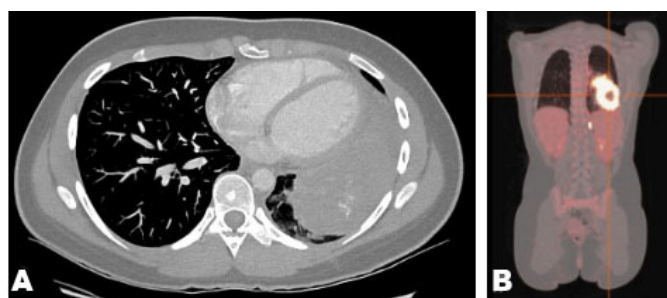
(A) Enhanced computed tomography (CT) of the chest revealed a large, solid mass with central mineralization. The mass showed contiguous involvement of the left pleura, left lower lobe, and left hilum, with compressive effect on adjacent lung tissue. (B) Positron emission tomography (PET) demonstrating intense hypermetabolism with central mineralization and necrosis.
